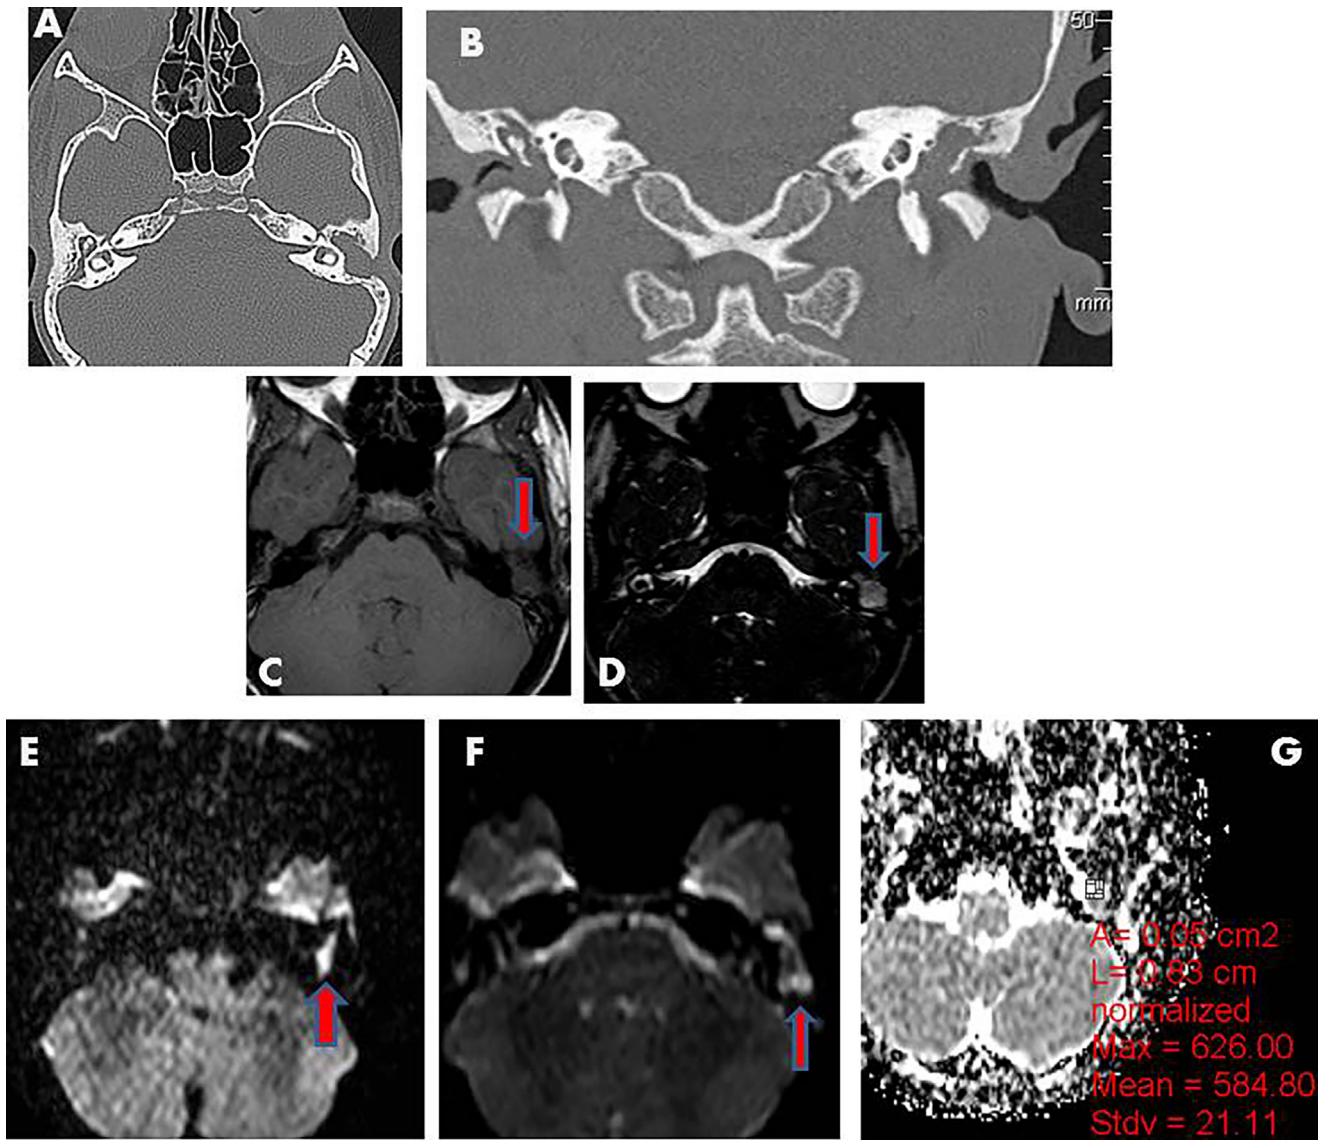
Recurrent cholesteatoma in the left middle ear of a 12y boy who underwent ICW middle ear surgery. (A and B) Axial and coronal CT cuts showed complete opacification of the left middle ear cleft by tissue density lesion associated with erosion of the ossicular chain. (C, D) Axial T1WI, axial CISS showed a soft tissue lesion in the left middle ear cleft of low signal in T1WI and high signal intensity in T2WI (red arrow). (E, F) Axial DWI obtained with a b factor of 1000 s/mm² showed markedly high signal intensity of the cholesteatoma (red arrow). (G) ADC (mean 584 × 10⁻³ mm²/s). The size of the lesion is 15 mm at CT and 10 mm at MRD. The right ear showed CSOM.
